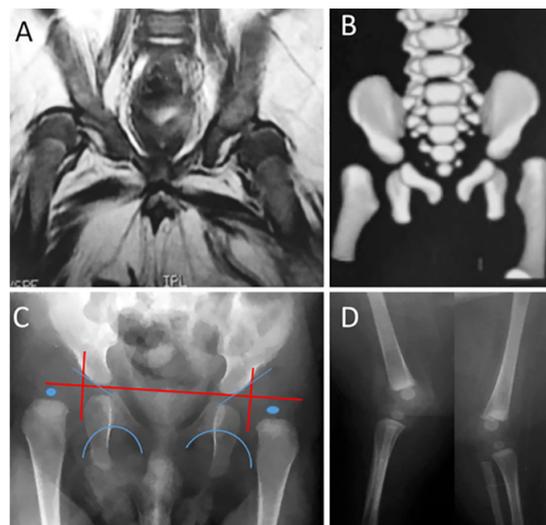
(A) Magnetic resonance image showing bilateral dislocation of hips, epiphyseal core (small arrow), and dysplastic acetabulum (large arrow); (B) 3D computed tomogram showing bilateral dislocation of hips; (C) anteroposterior radiographs showing features compatible with dislocation of hips: interruption of Shenton's arc, epiphysis hypoplastic proximal femoral acetabular index of 35 degrees, and right and left proximal femoral epiphysis located laterally on side and bottom quadrant ombredanne; (D) radiograph shows subluxation of knee (arrows)
